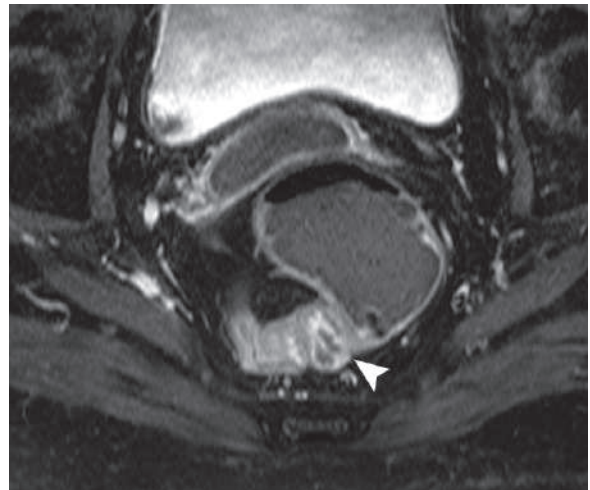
Axial T1W, fat-saturated, postcontrast MRI in a patient with UC shows focal rectosigmoidal bowel wall enhancement indicating acute inflammation (*arrowhead*)
